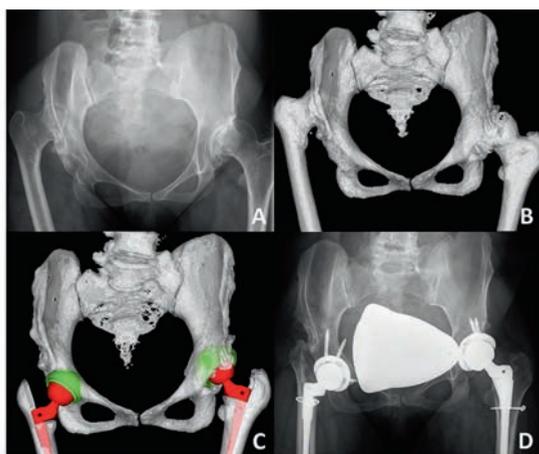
3D-CT planning can guide surgical decision-making for complex hip cases. A) AP radiograph of a 46 year old woman with severe bilateral DDH and inability to cope with walking. B) This case was planned with 3D-CT software (Zedhip® LEXI Co.). C) Modular S-ROM stems were chosen to bring the centres of hip rotation to their correct anatomical position, keeping them as symmetrical as possible. D) Post-op AP radiographs showed that the pre-operative plan was achieved, and at 1-year follow up the patient is satisfied with her improved walking ability.
